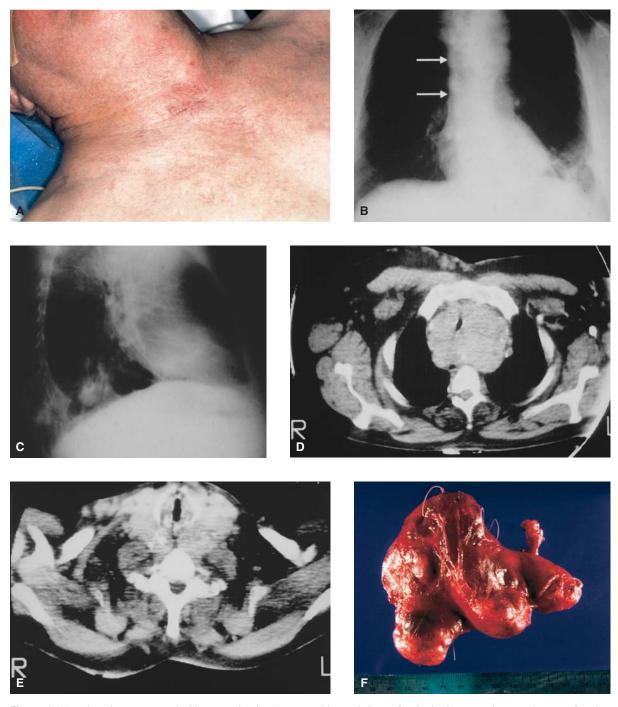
A patient presented with worsening inspiratory stridor and discomfort in the lower neck several years after thyroidectomy for multinodular goiter. *A*, Prominent venous collaterals secondary to superior vena caval obstruction by a recurrent substernal goiter. *B*, A posteroanterior radiographic view of a chest shows absence of the superior vena cava from the cardiac silhouette (*arrows*). *C*, A lateral radiographic view of the chest shows a mass in the superior mediastinum. *D*, Chest computed tomographic (CT) scan reveals tracheal compression by the retrosternal goiter. *E*, Neck CT scan shows that the goiter extends to the level of the thyroid cartilage, causing airway compression. Awake intubation under fiberoptic laryngoscopy is the safest way to intubate this patient. *F*, Gross appearance of the goiter. Note the prominent nodularity.
